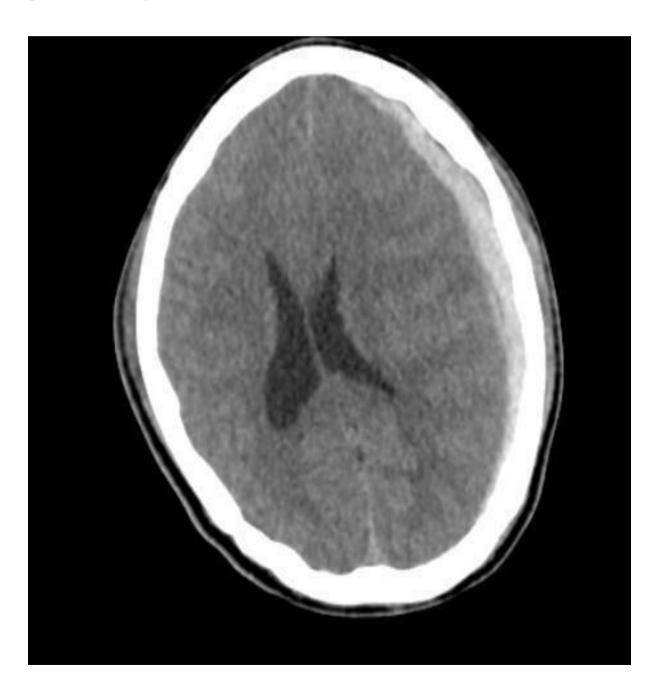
Axial CT scan brain demonstrates Extradural hemorrhage in the left parietal region with few hypodense areas within showing "Swirl sign" suggestive of active bleeding
